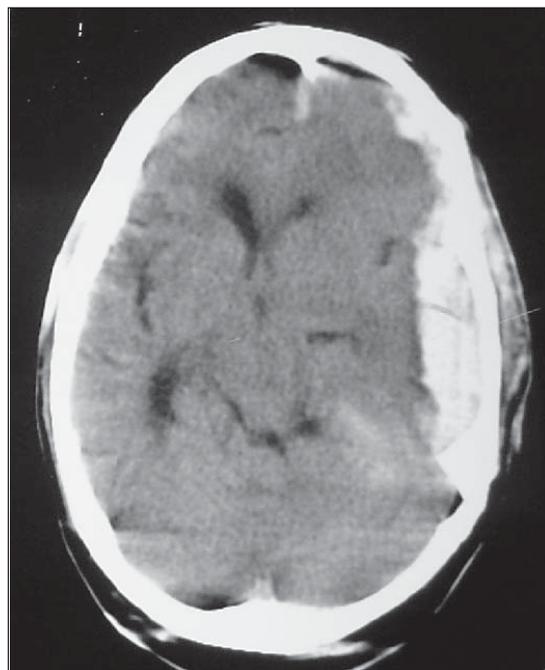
Plain CT head of a 14 year old child who developed subdural bleed after 48 hours of injury and who was found to have a deranged coagulation profile (The initial CT at 12 hours of injury was normal)
